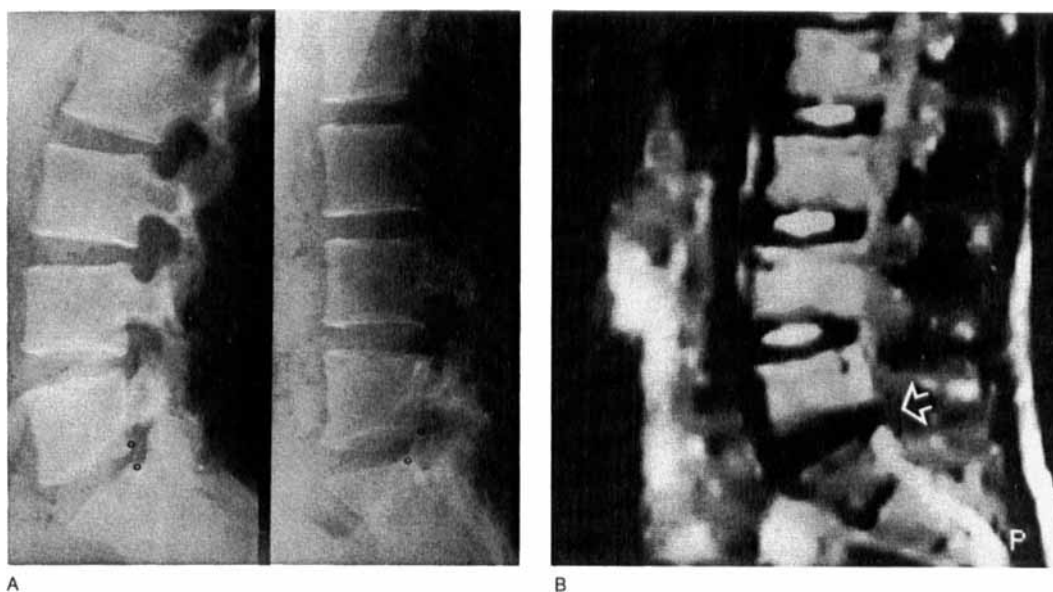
Flexion-extension radiographs (A) of a patient with low back pain and lumbar instability. The shear was 5 mm in the L5-S1 space. The T2-weighted (SE 1000/100) MR image (B) indicates that the nucleous pulposus of the L1-L5 spaces is normal (high-intensity signals). Disc dehydration is seen in the unstable presacral space (absence of MR signal, arrow).
